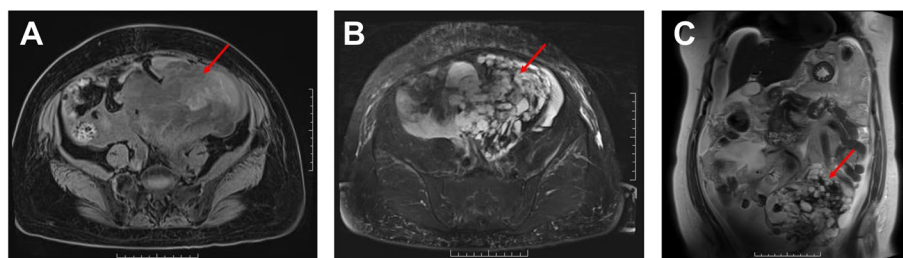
Magnetic resonance imaging: a large, irregular, multilocular, solid-cystic, and complex signal mass shadow, which is closely associated with the intestine (arrows). The liquid level can be seen locally inside. The solid part was isointense on both T1 and T2 images. (A) T1 imaging, transverse plane; (B) T2 imaging, transverse plane; (C) T2 imaging, coronal plane)
